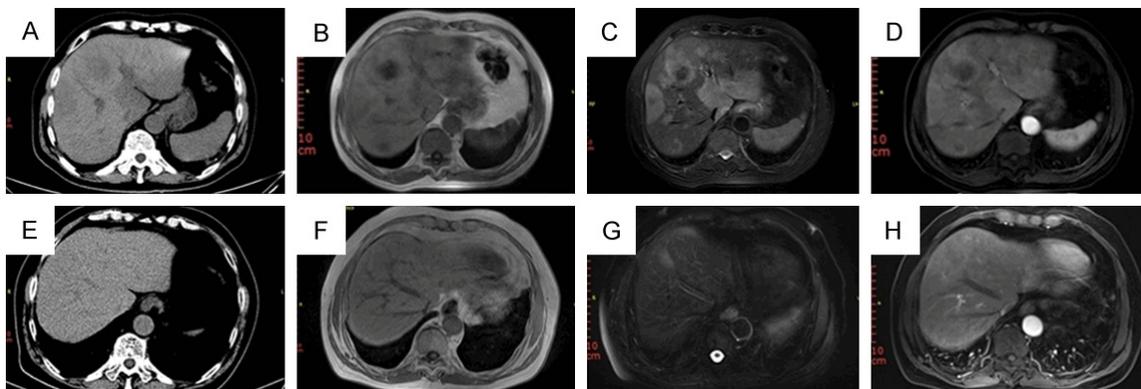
Before chemotherapy: (A) Plain abdominal CT showing multiple hypodense areas in the liver. (B) T1-weighted MRI image showing multiple diffuse slightly hypo-intense lesions. (C) T2-weighted MRI image showing slightly hyper-intense lesions. (D) T2-weighted MRI image showing enhancement in the arterial phase after injection. After chemotherapy: (E-H) Corresponding images showing a complete resolution of the tumor.
